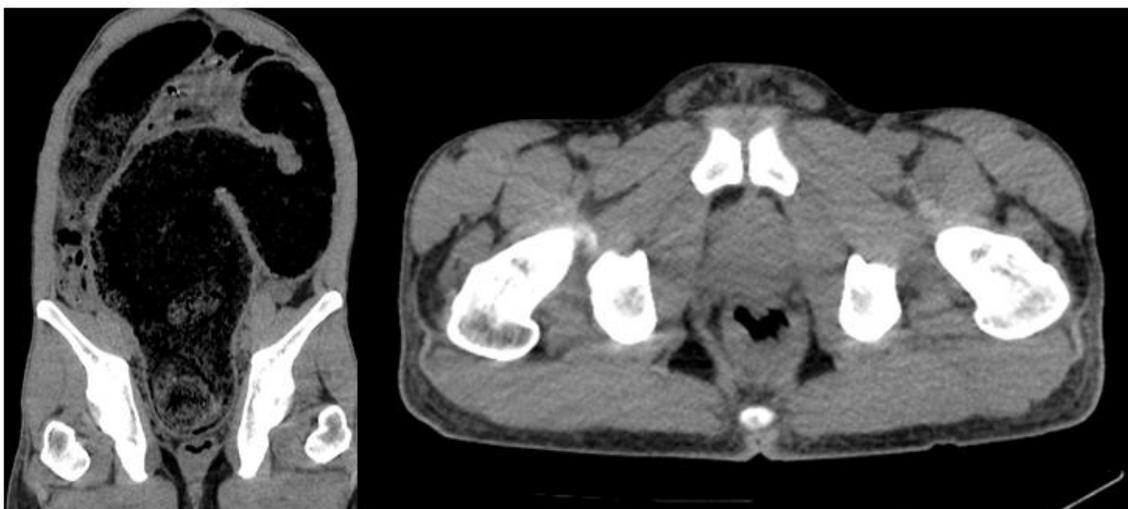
5: CT scan without injection, axial and coronal sections, showing sigmoid dilatation with empty rectal ampulla without parietal thickening antero-posterior diameter.
